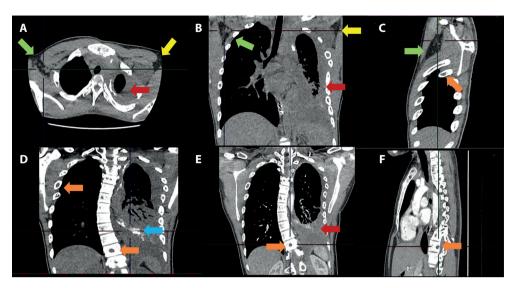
Chest CT scan, mediastinal window. A, B, C, D, E, F. Diffuse pleural thickening and pleural effusion with an average density of 18 Hounsfield units (HU) are observed on the left side (red arrows), calcifications of the visceral pleura in the left lower lobe (blue arrow). Cystic lesions with poorly defined borders extending into the axillary area are seen in the supraclavicular fossae, identified with green arrows on the left side and yellow arrows on the right side. Additionally, there is scoliosis with convexity to the right and multiple lytic lesions in the ribs and vertebral bodies (orange arrows).
